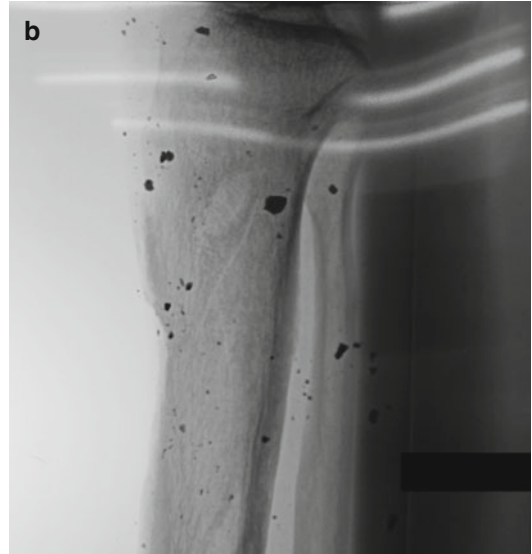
(a) This young man was a casualty during a suicide bomber attack. Unfortunately, he developed multiple sinuses secondary to bone infection. (b) X-ray showing the shrapnel in the tibia
